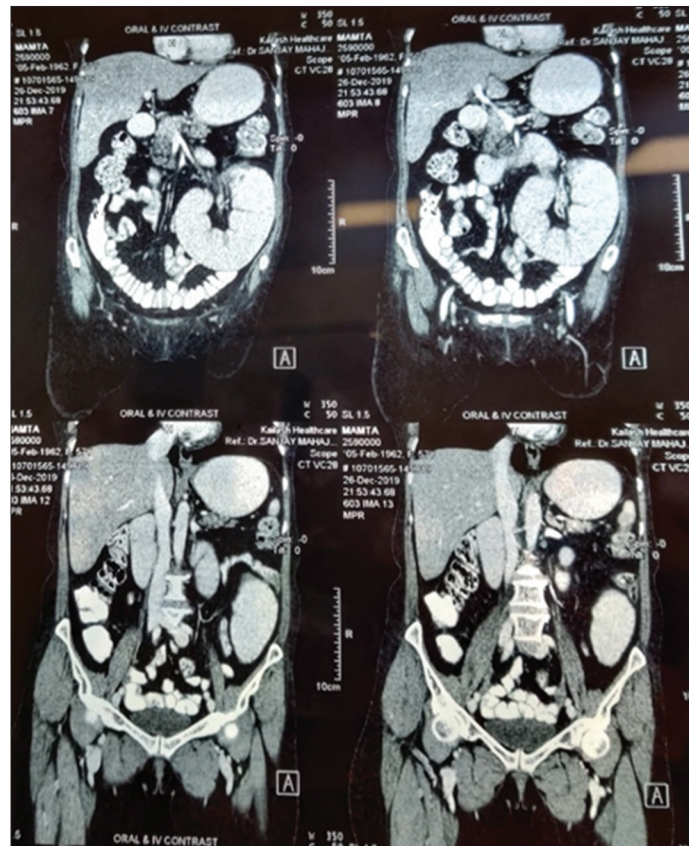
Computed tomography scan abdomen showing circumferential short segment wall thickening of proximal jejunum with upstream dilatation of jejunum, duodenum, and stomach, however, there was passage of the contrast distally
